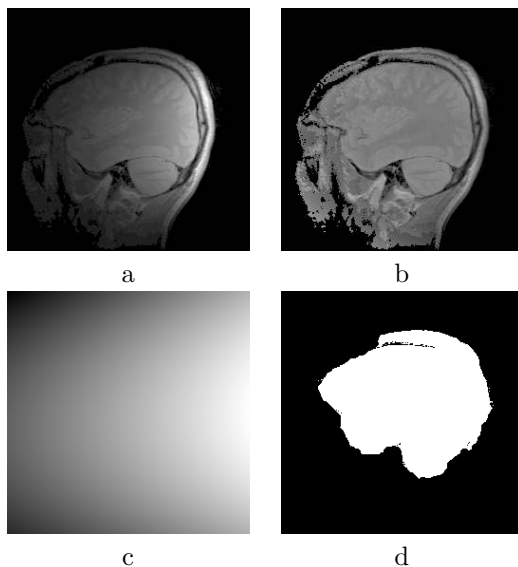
Bias field correction of a sagittal head MRI image (classes white and gray matter; Legendre polynomials up to second degree): a: Original image. b: Corrected image. c: Computed bias field. d: Class-mask
